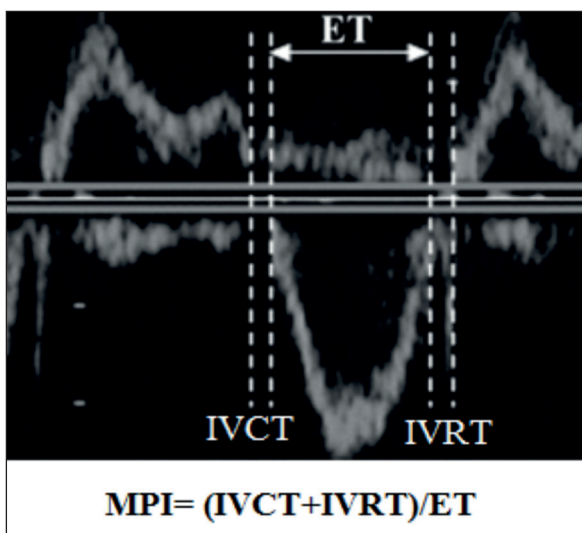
Doppler Echocardiographic display of MPI calculation. IVRT: isovolumic relaxation time, IVCT: isovolumic contraction time, ET: ejection time.
